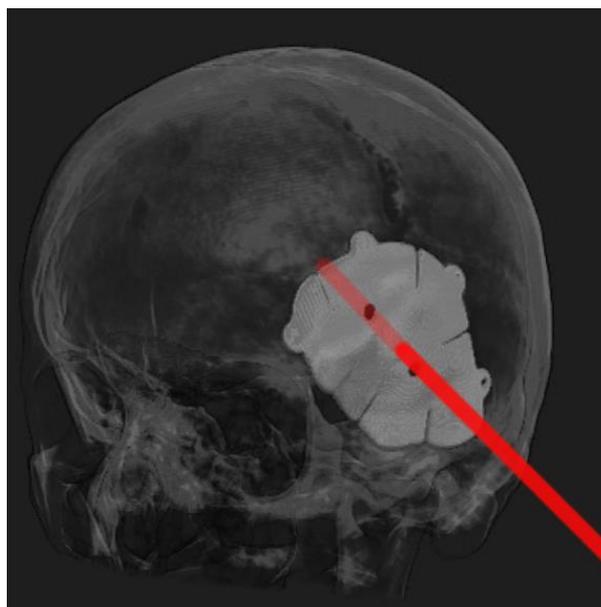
Volume rendered CT image of our patient showing our impression of the trajectory of the iron bar traversing the skull (titanium plate also visible).
